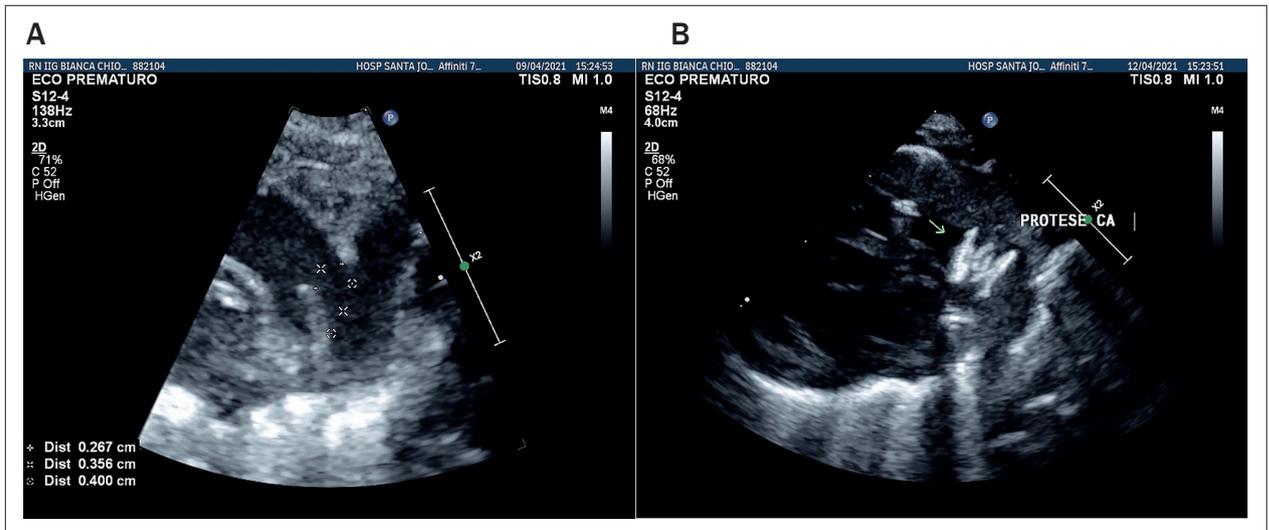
A) Echocardiogram performed during the procedure, with measures of the diameters in the aortic and pulmonary ends and ductus length. B) Echocardiogram performed immediately after the release of the device so as to dismiss residual injury such as left pulmonary artery or aorta stenosis.
